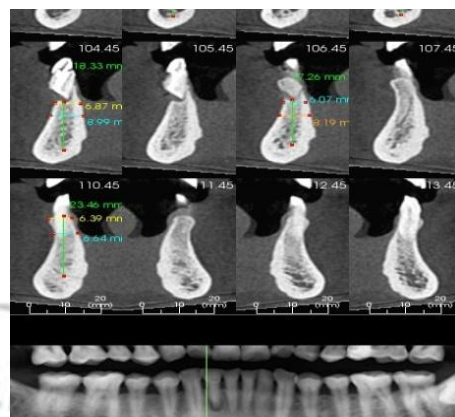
Preoperative diagnostic CT scan
